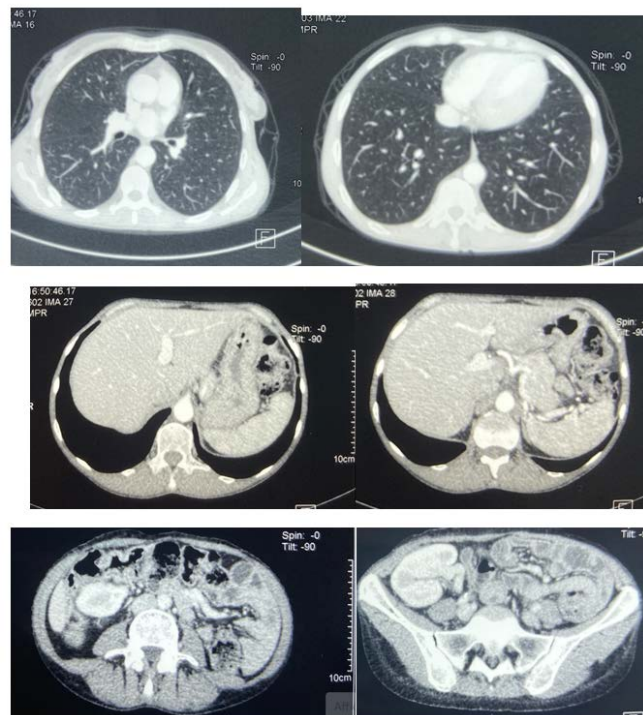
Normal thoraco-abdomino-pelvic CT scan, 14 months after Chemotherapy and reduction of immunosuppression.
